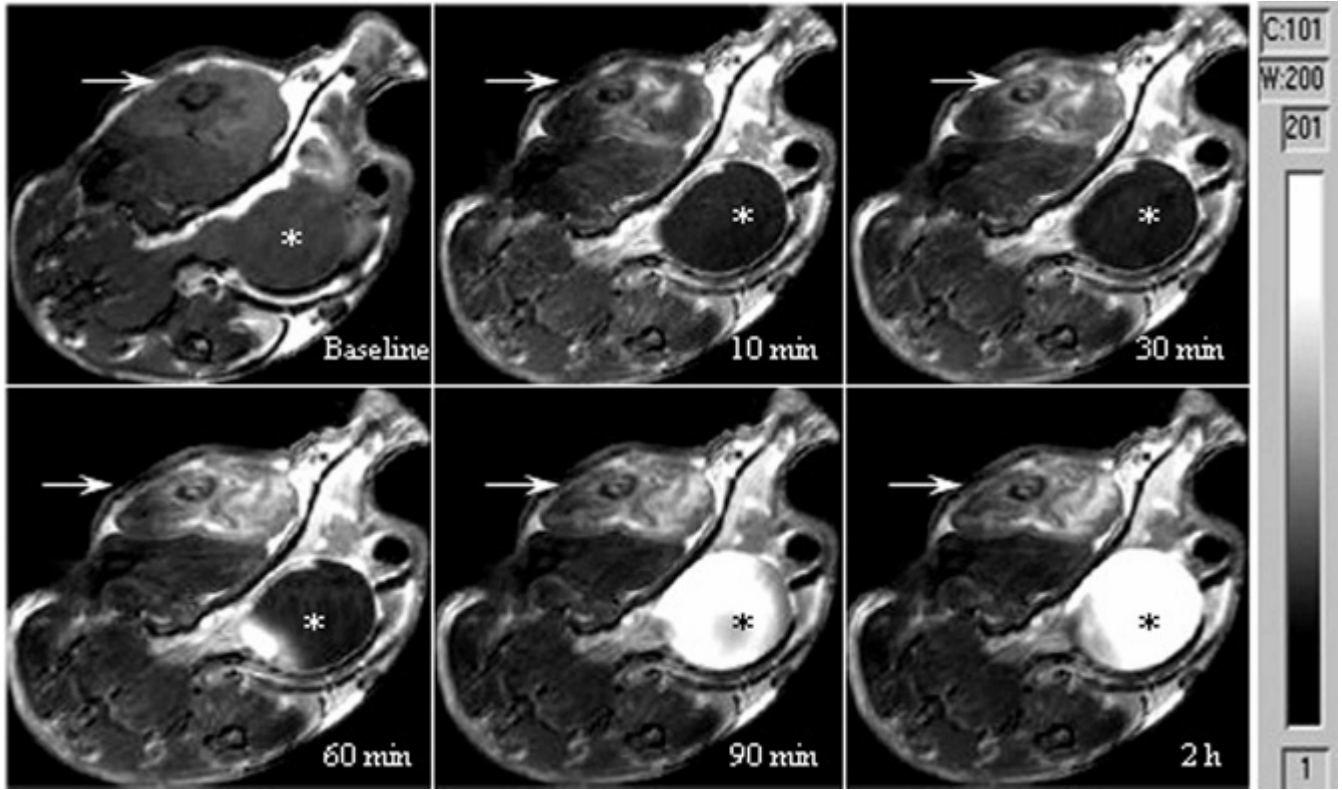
In vivo time course of tumor magnetic resonance imaging (MRI) after intravenous administration of the probe transferrin-liposome-nitrobenzoxadiazole-contrast agent ($\text{Tf}^{\text{NIR}}\text{-Lip}^{\text{NBD}}\text{-CA}$) showing gradually increased enhancement of the tumor signal (arrow) and a heterogeneous enhancement pattern. Gradual accumulation of contrast agent in the urinary bladder is evident (*). The MRI parameters are as follows: echo time = 11.416 milliseconds, repetition time = 800 milliseconds, number of averages = 4, field of view = 28×30 mm, matrix size = 256×192 , and slice thickness = 1.0 mm.
